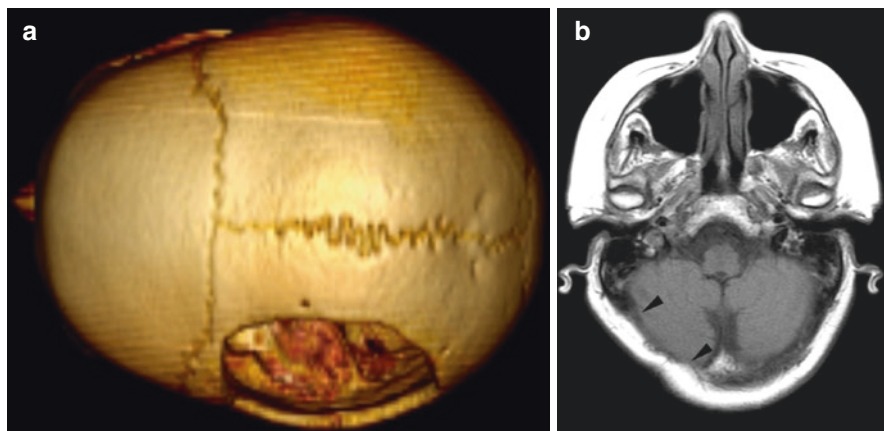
(a) Subtemporal craniectomy in a 37-years-old man for removing infected bone flap. Volume-rendered CT image (a) shows subtemporal craniectomy. (b) A suboccipital craniectomy in an 85-year-old female, as demonstrated by a gap in the calvaria in an axial T1 sequence
